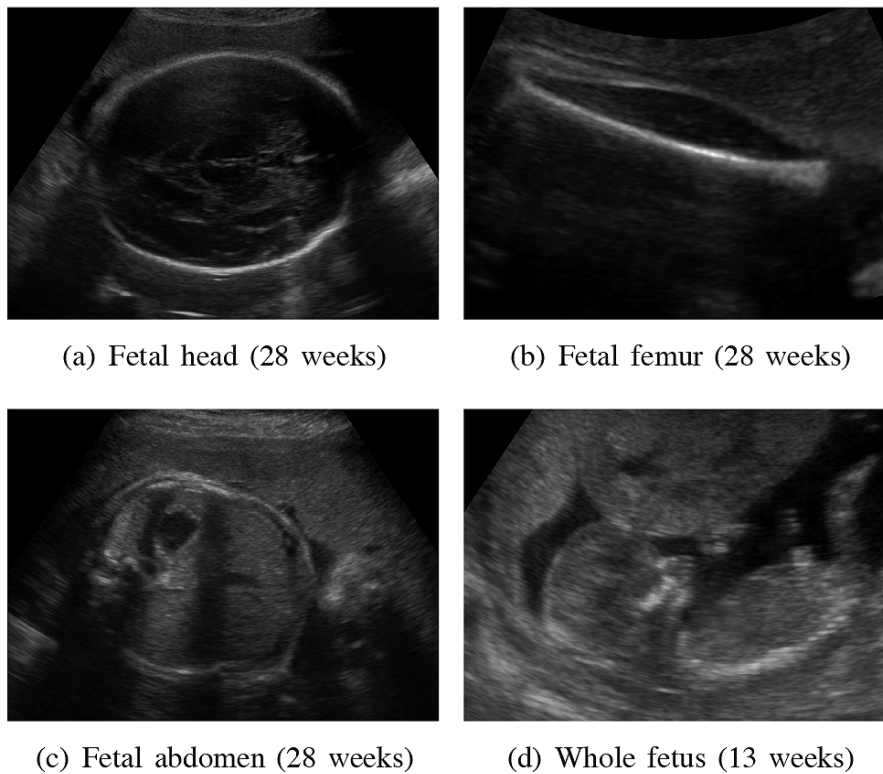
Ultrasound images of the (A) fetal head, (B) fetal femur, (C) fetal abdomen, and (D) the whole fetus. Figure taken with permission from [220].
